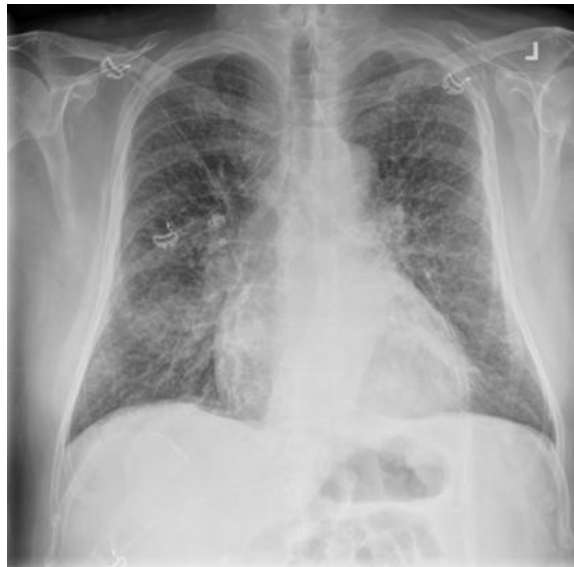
Chest x-ray from second admission.
